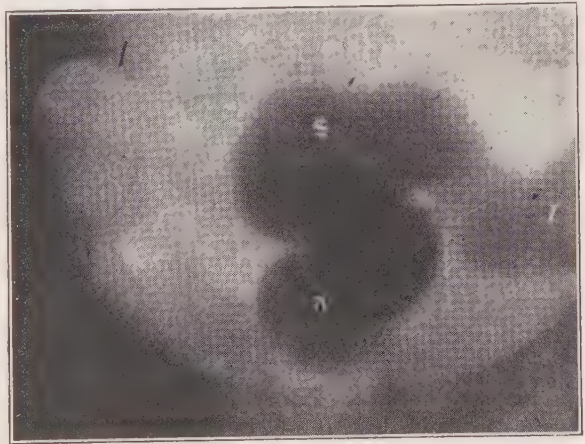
ROENTGENOGRAM OF NORMAL RECTUM, SIGMOID, AND ILIAC COLON.
